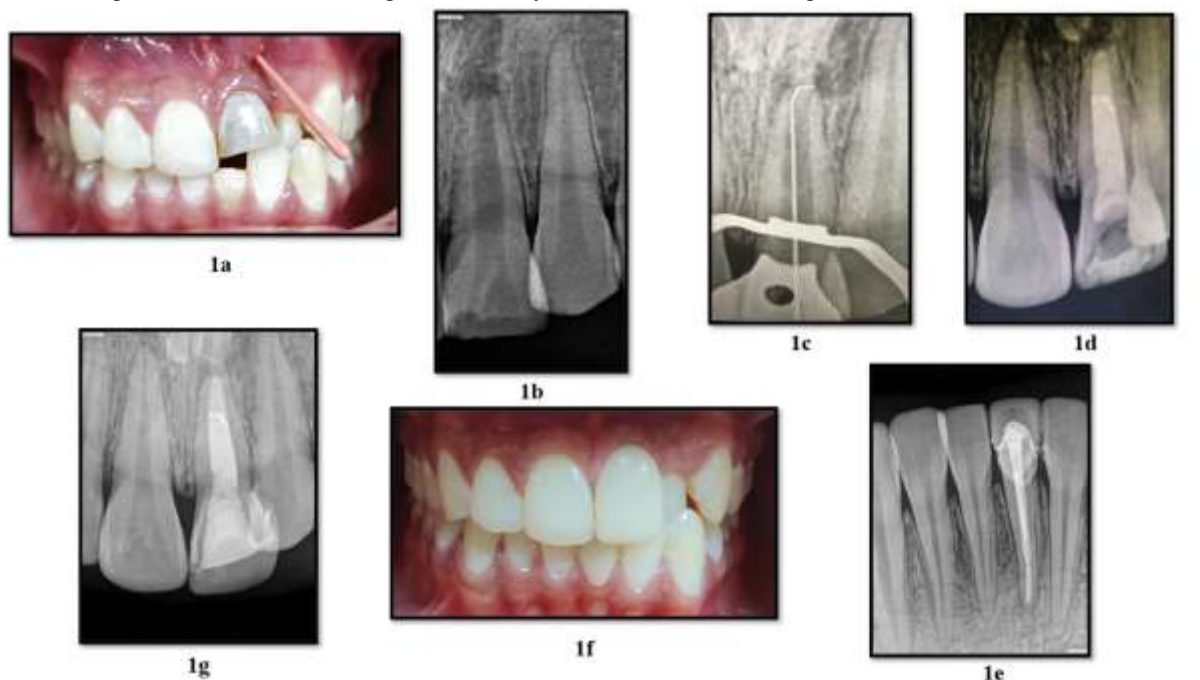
(1a) Clinical picture showing maxillary and mandibular anterior teeth and gingival tissue with sinus tract and tracing, (1b) Radiographic representation of maxillary central incisor with periapical radiolucency, (1c) Radiograph representing of working length determination, (1d) Radiograph representing of apical plug and obturation, (1e) Radiograph representing post and core with 31, (1f) Post – operative picture of 21 and 31, (1g) Post –operative radiograph of 21 at 1.5 year follow-up.
